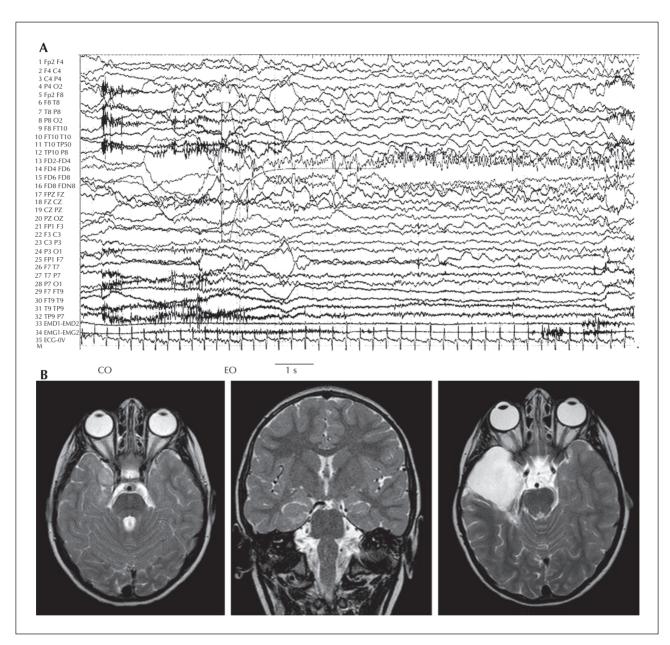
Patient 15. (A) Scalp EEG recording combined with a foramen ovale electrode (FOE) (*see video sequence 2*). Spike-and-wave discharge is seen on the FOE, then diffuse delta activity on the right hemisphere (longitudinal montage with supplementary temporo-basal electrodes and the FOE, the electrode FO 2 being the most posterior). The seizure probably originates from the amygdala which is not explored with FOE. CO: clinical onset; EO: before electrical onset. (B) Preoperative contrast-enhanced MRI showing a right amygdala lesion and postoperative follow-up showing a temporal pole resection.
